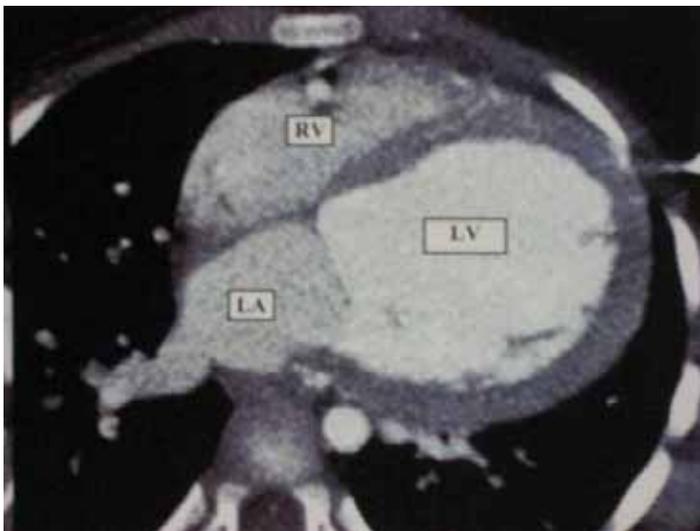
A cardiac CT angiography revealing our 2 year old patient's marked left ventricular dilatation.
